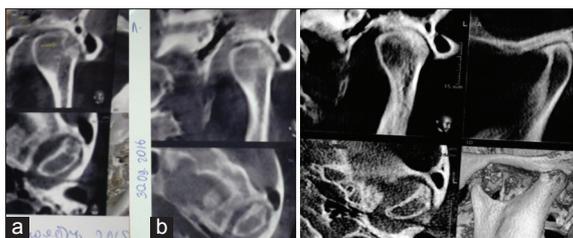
Computed tomography in comparison: (a) - before the onset of treatment (November 2015), (b) - after treatment (September 2016), (v) - control examination (July 2018)
